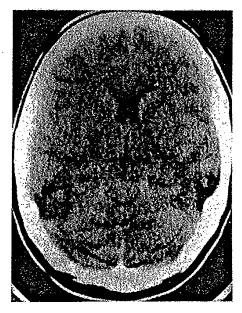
Case 5 CT brain scan showing diffuse cerebral oedema and multiple infarcts in both parietal and occipital lobes.
